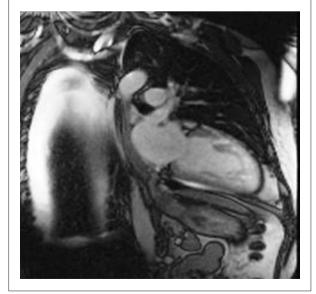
Magnetic resonance imaging of noncompaction of the LV apical region.
